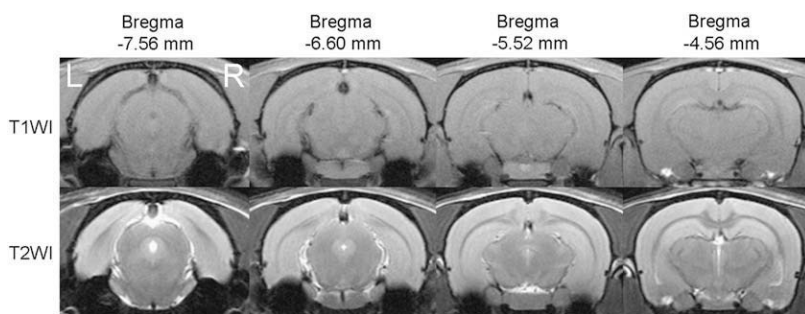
Typical T1-weighted and T2-weighted images of the visual cortex at Bregma -7.56 mm to -4.56 mm. No apparent difference was observed between contralateral sides of the visual cortex.
